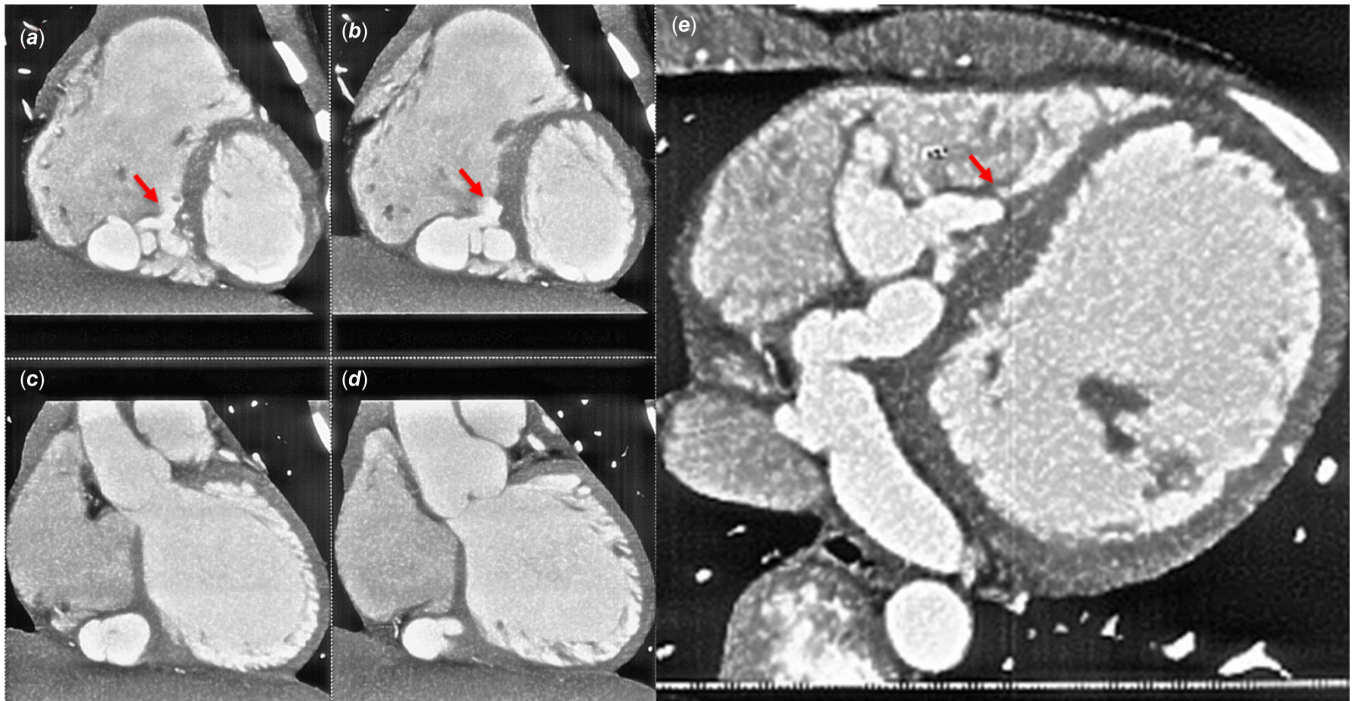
a–d.* Cardiac contrast CT in coronal section showing hugely dilated left circumflex artery draining (arrow) into right ventricle via inter-ventricular septum; *e.* Axial contrast computed tomogram showing the same (arrow).
